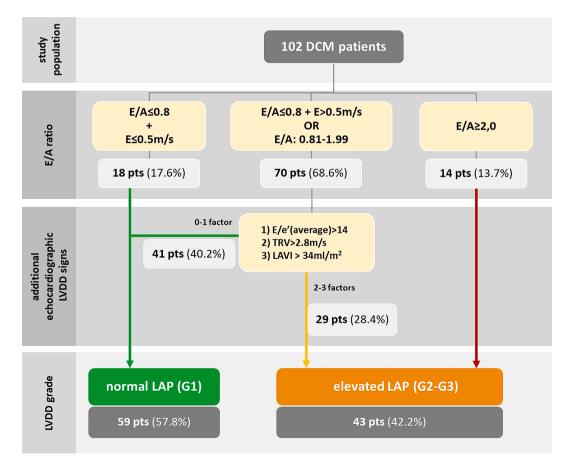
Left ventricle diastolic function assessment with echocardiography. Abbreviations: G1 – normal or mildly abnormal LV diastolic function, G2 – moderate or severe LV diastolic dysfunction, LAP – left atria pressure, LAVI – left atria volume index, LVDD – left ventricle diastolic dysfunction, TRV - peak tricuspid regurgitation velocity.
